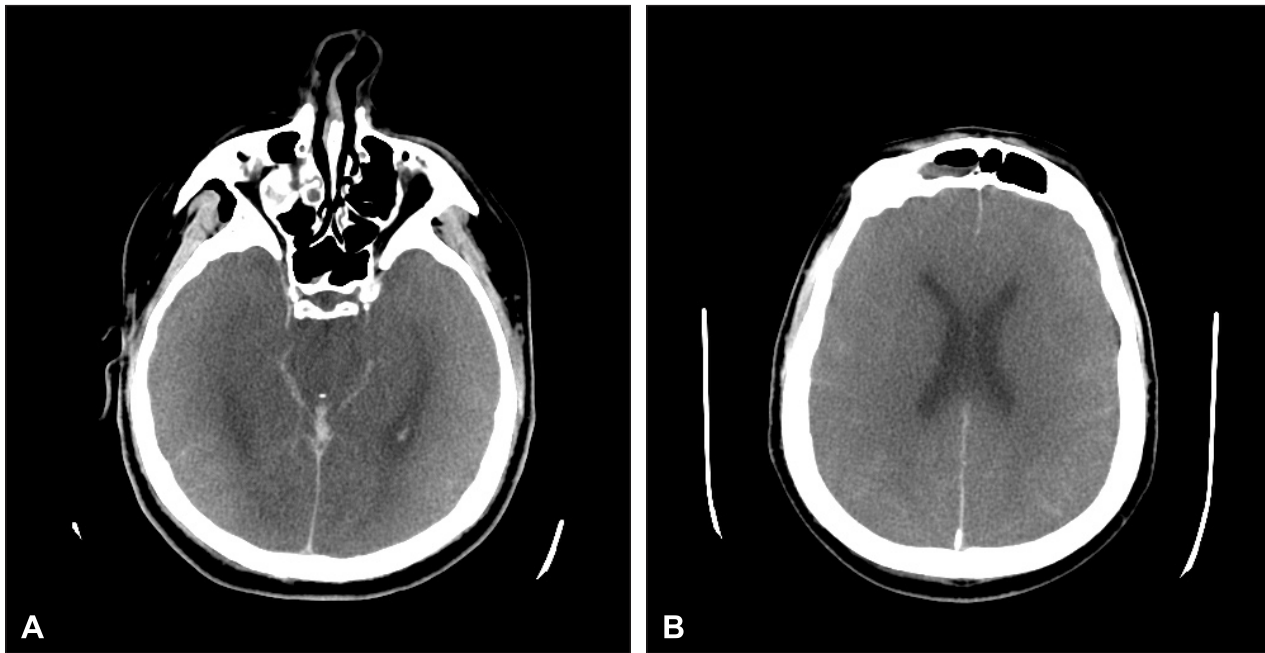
Non contrast head CT scan demonstrates diffuse cerebral edema with subarachnoid hemorrhage (A and B).
